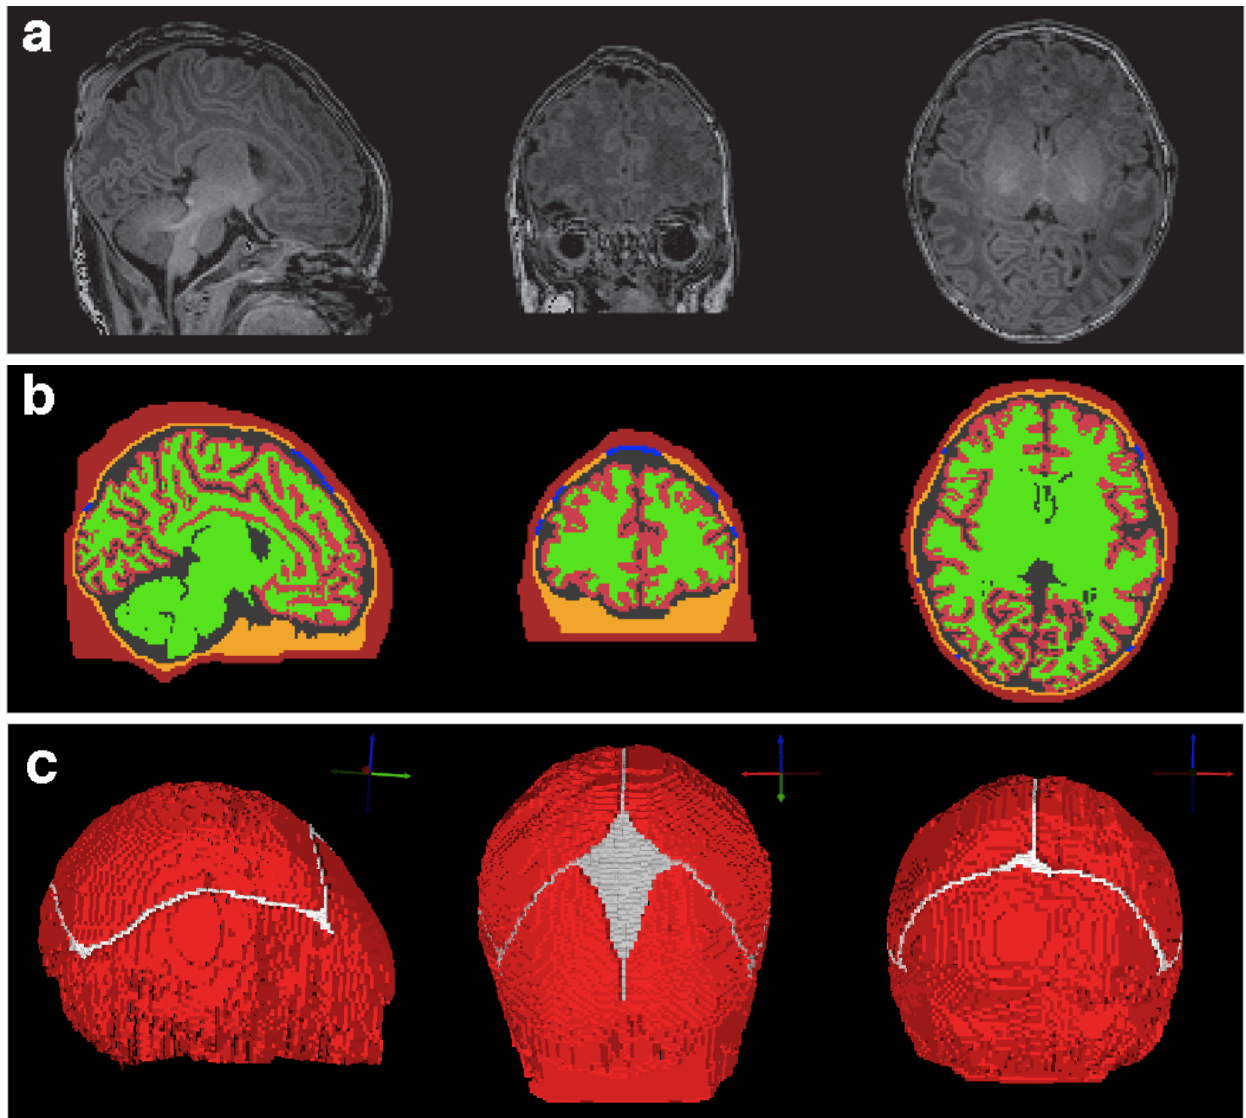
(a). MR images of the Infant in sagittal, coronal, and axial slices. (b) Segmentation of different tissue types featuring sutures and fontanelles (in blue) on the same cross sections as in (a). (c) The skull compartment with sutures and fontanelles viewed from front, right, and back. Skull is shown in red, sutures and fontanelles in white.
